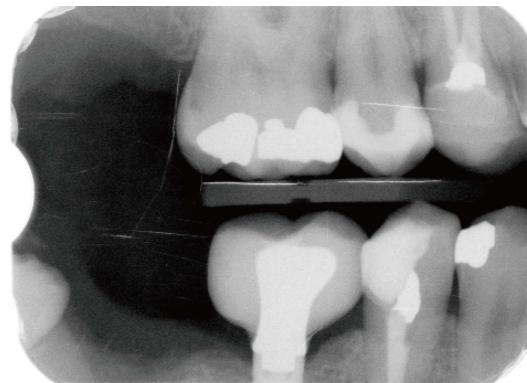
Post-treatment radiograph after second molar extraction.
